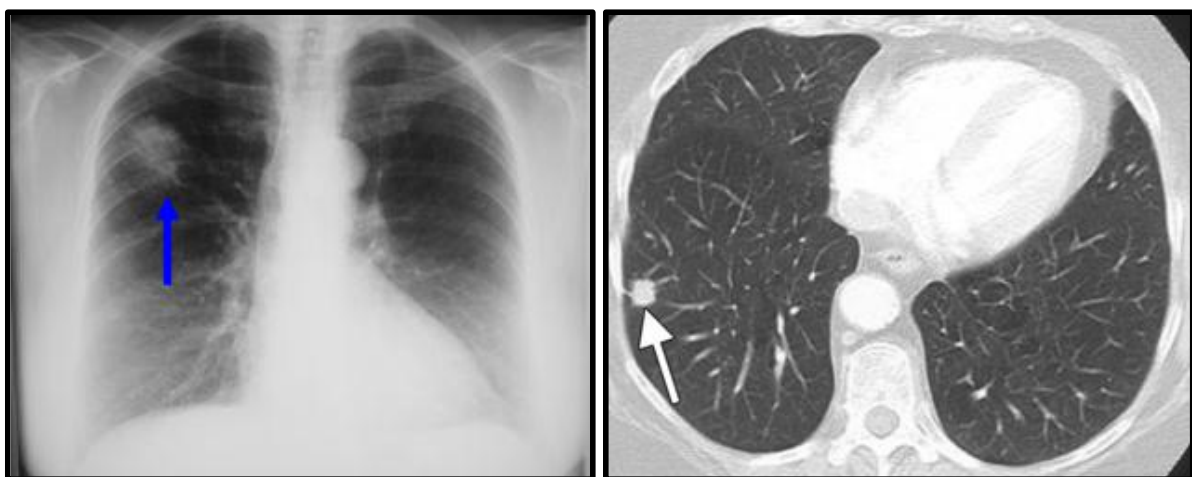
On the left is an abnormal Chest X-Ray showing a cancer in the patient's right lung (blue arrow) and on the right is CT scan shows dominant pulmonary nodule (white arrow) in right lower lobe that proved at pathology to be adenocarcinoma (adapted from [17] and [18]).
